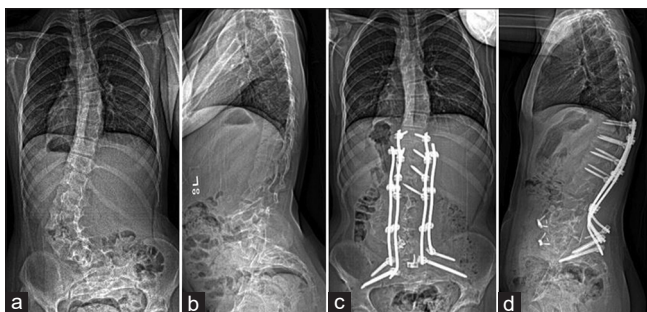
Preoperative (a and b) and 2 years postoperative (c and d) standing radiographs of the spine of our patient with dystrophic Type 1 neurofibromatosis
